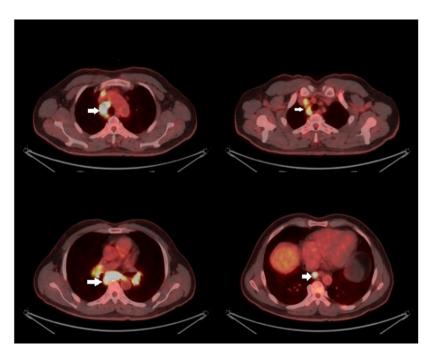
<sup>18</sup>FDG PET/CT maximum intensity projection and <sup>18</sup>FDG PET/CT axial slice images at diagnosis. Images showed pathological FDG uptake in the bilateral supraclavicular regions, mediastinum, bilateral hilar and left cardio-diaphragmatic angle, with pathological uptake (maximum standardized uptake value=19.49). <sup>18</sup>F-FDG, 18F-fluorodeoxyglucose. White arrows indicate pathological FDG uptake regions.
